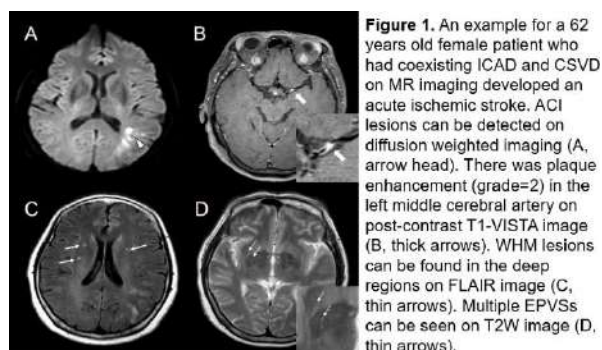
An example for a 62 years old female patient who had coexisting ICAD and CSVD on MR imaging developed an acute ischemic stroke. ACI lesions can be detected on diffusion weighted imaging (A, arrow head). There was plaque enhancement (grade=2) in the left middle cerebral artery on post-contrast T1-VISTA image (B, thick arrows). WMH lesions can be found in the deep regions on FLAIR image (C, thin arrows). Multiple EPVSs can be seen on T2W image (D, thin arrows).
